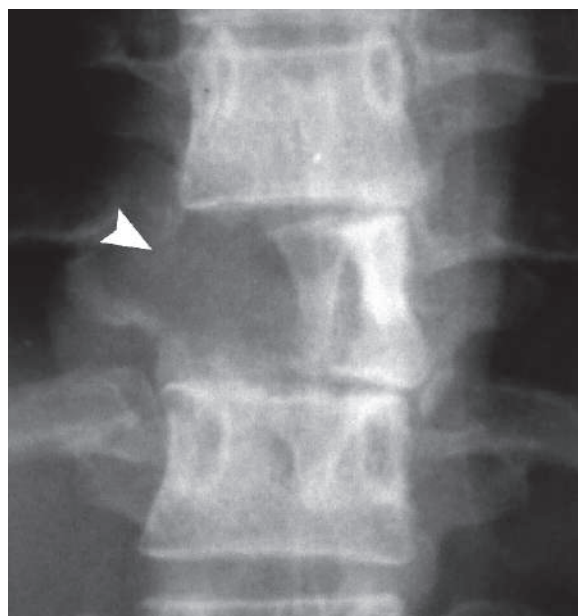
Anteroposterior thoracic vertebral plain radiograph shows punched-out lytic lesion affecting the vertebral body in a patient with Langerhans cell histiocytosis (LHC) (arrowhead)
